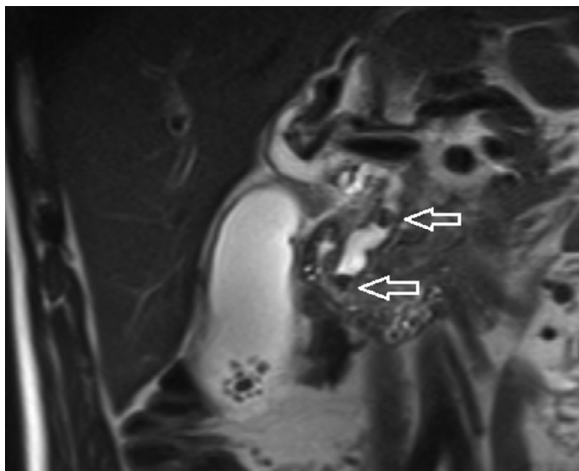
A 53-year-old man patient suffering from acute right upper quadrant abdominal pain underwent abdominal magnetic resonance imaging. Coronal T2-weighted image revealed 2 stones in the common bile duct (arrows) and multiple gallbladder stones
